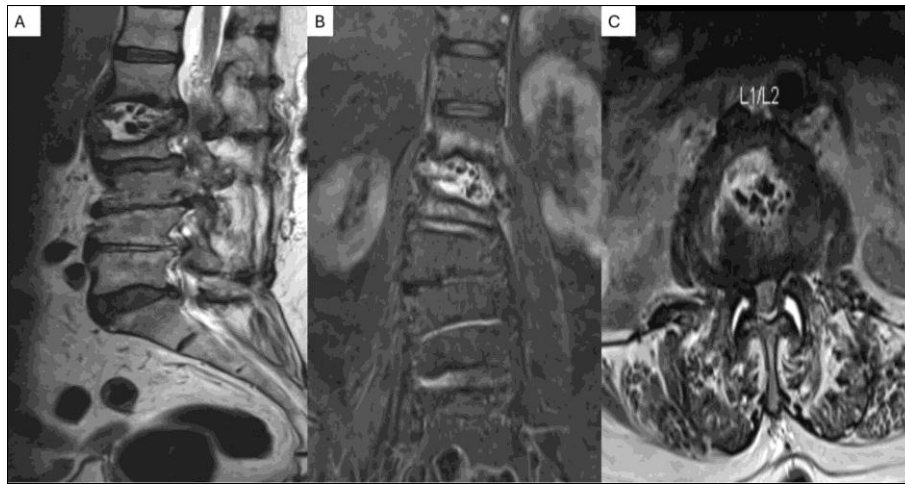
Eight-month post-L2 vertebroplasty follow-up Magnetic resonance imaging scan – showing a hyperintense fluid-filled cavity at L1-2 disc space on T2-weighted image with fragmentation of PMMA cement. A) Sagittal section B) Coronal section C) Axial section
